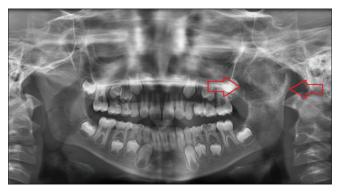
Panoramic radiography showing a lesion on left temporomandibular joint involving ramus and coronoid process extending till sigmoid notch
